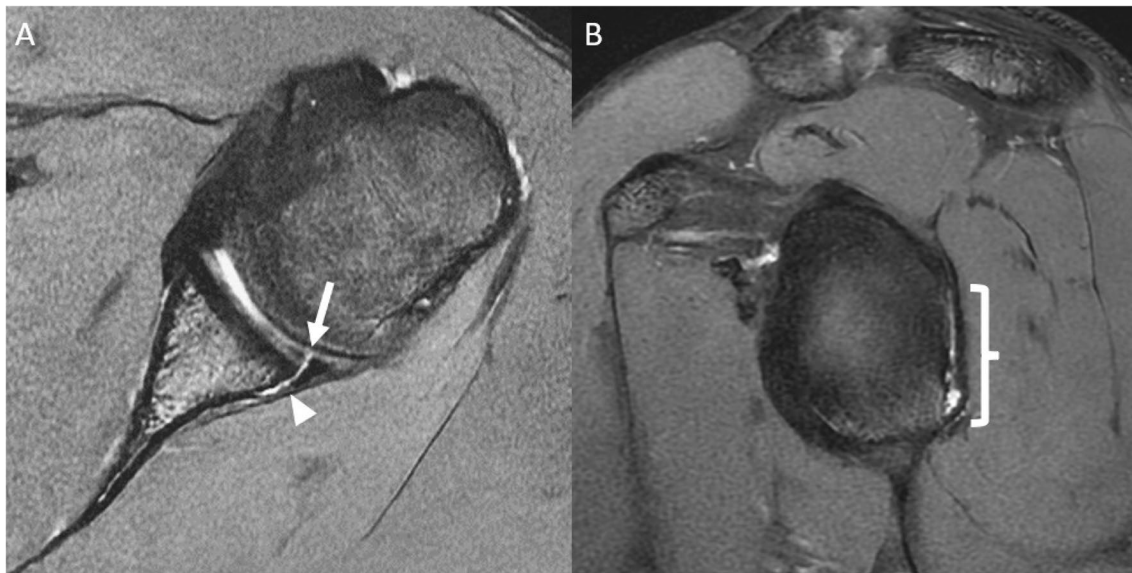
Axial (A) and sagittal (B) T2 fat-saturated MR images demonstrate a tear of the posteroinferior chondrolabral junction (arrow) with associated stripping of the posterior glenoid periosteum (arrowhead)
